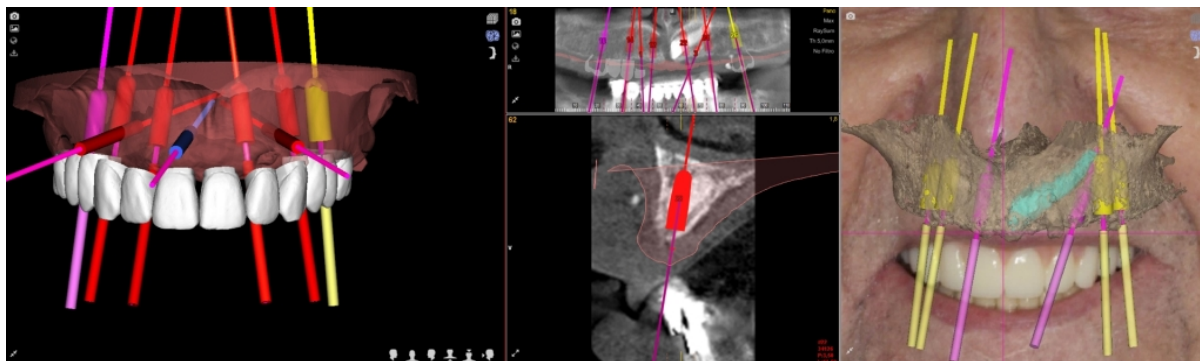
Smile frame, 3D scan model and CBCT superimposed in the Nemo DSD Guided Surgery software.
